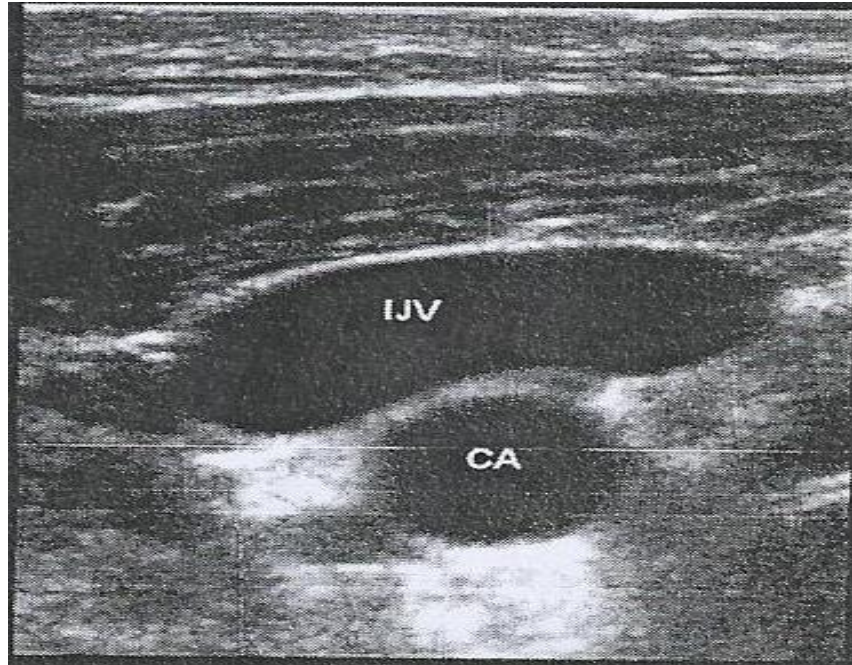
Ultrasound image in short axis view showing right internal jugular vein completely overlapping the right carotid artery from the data collected
